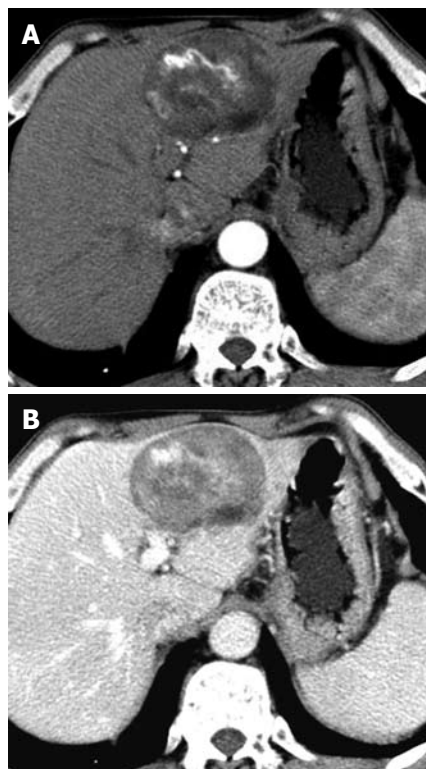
Patient with sporadic hepatic angiomyolipoma. A: Enhanced CT showed one well-defined, fat-containing nodule with prominent central vessels in the arterial phase; B: Enhanced CT showed sustained contrast enhancement of the intratumoral non-fat component in the portal venous phase.
